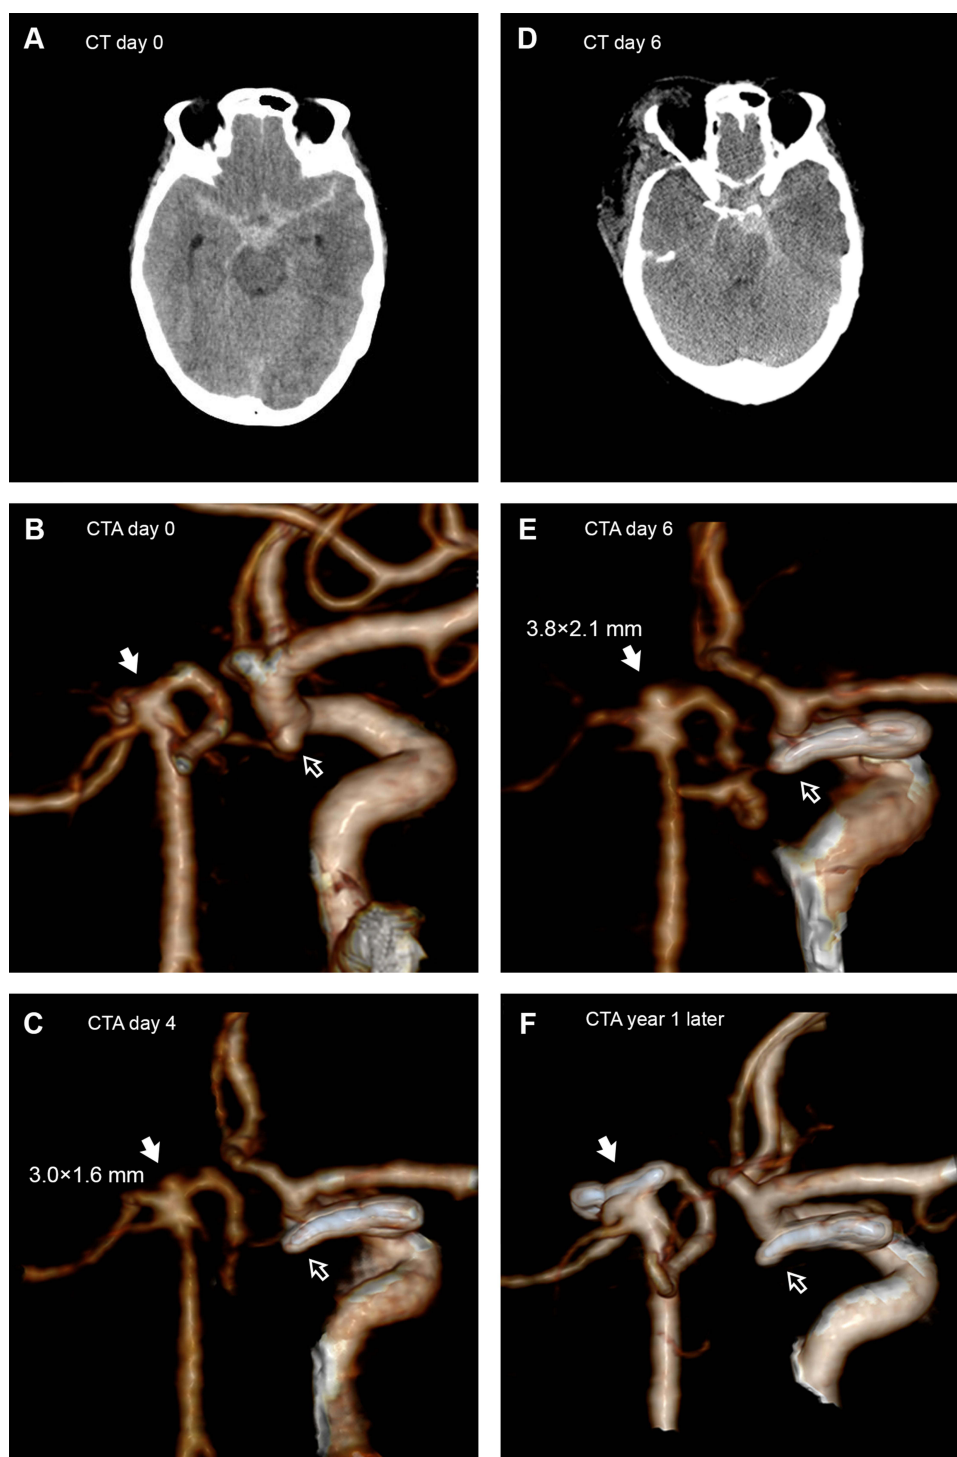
Rapid development and rupture of a de novo terminal basilar artery aneurysm. (A) The initial CT scan revealed a supratentorial SAH. (B) Subsequent CTA (day 0) identified a 3.0×1.8 mm intracranial aneurysm on the right PComA, presented here in a three-dimensional reconstruction image (empty arrow). The anatomy of the basilar trunk and tip is normal, with no indication of an aneurysm (filled arrow). (C) CTA postoperative 4 days confirmed that the PComA aneurysm was completely clipped with the PComA preserved. Preservation of the clip is shown in the three-dimensional reconstruction image (empty arrow). However, a new 3.0×1.6 mm aneurysm was found at the terminal basilar artery (filled arrow). (D) A new infratentorial SAH was shown by CT postoperative 6 days later. (E) Enlargement of the terminal basilar artery aneurysm (3.8×2.1 mm) was disclosed by postoperative CTA 6 days (filled arrow), and the aneurysm had ruptured, as evidenced by the location of SAH shown on CT (D). (F) CTA follow-up performed 1 year after the second clipping indicated that both aneurysms were completely occluded, and no DNAs were detected.
